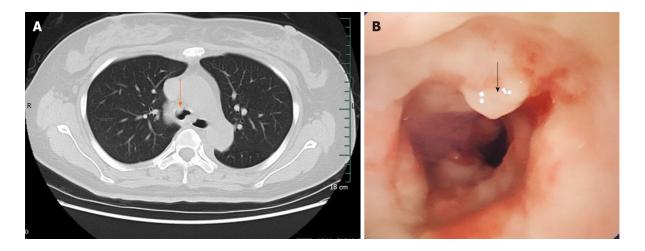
Lung computed tomography findings and the first tracheoscopy. A: Lung computed tomography; B: Tracheoscopy. The main bronchus was occupied.
